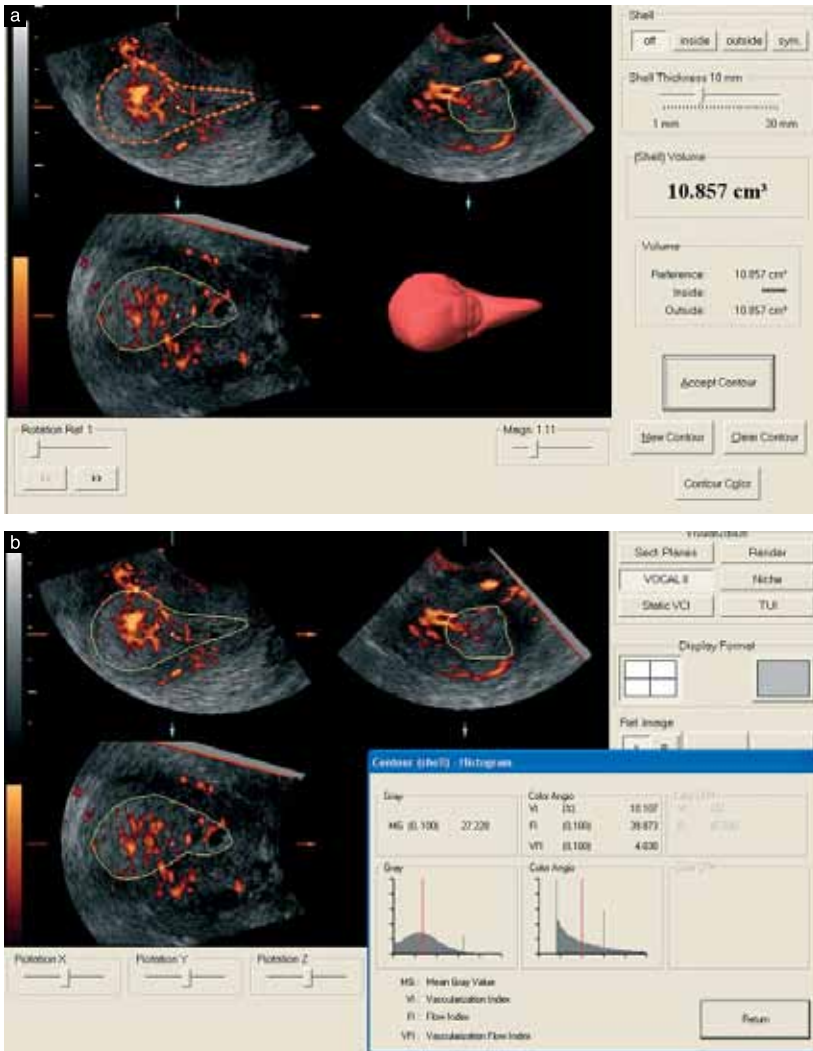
Calculation using VOCAL™ software of endometrial volume (a) and power Doppler indices (vascularization index (VI), flow index (FI) and vascularization flow index (VFI)) in the endometrium (b).
